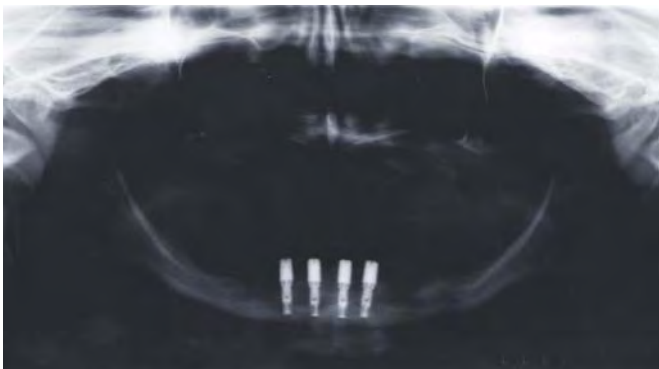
Panoramic radiograph showing four endosteal implants with healing abutments in situ.
